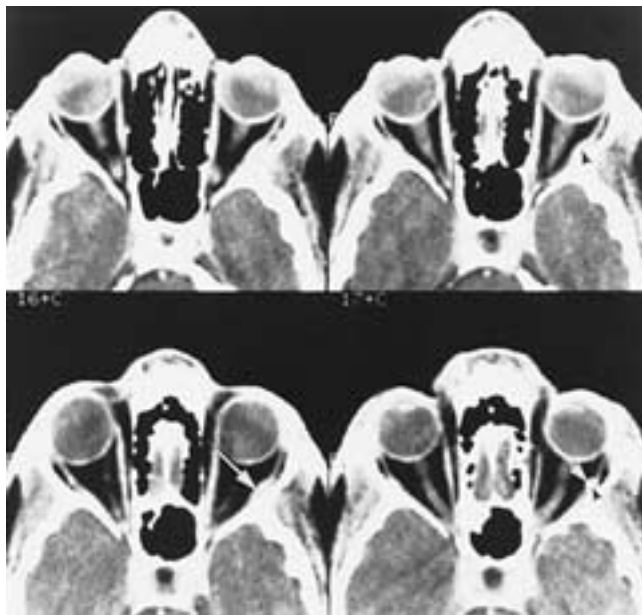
Hemangioma. Serial axial contrast-enhanced CT scans show an intramuscular hemangioma (*arrows*).
